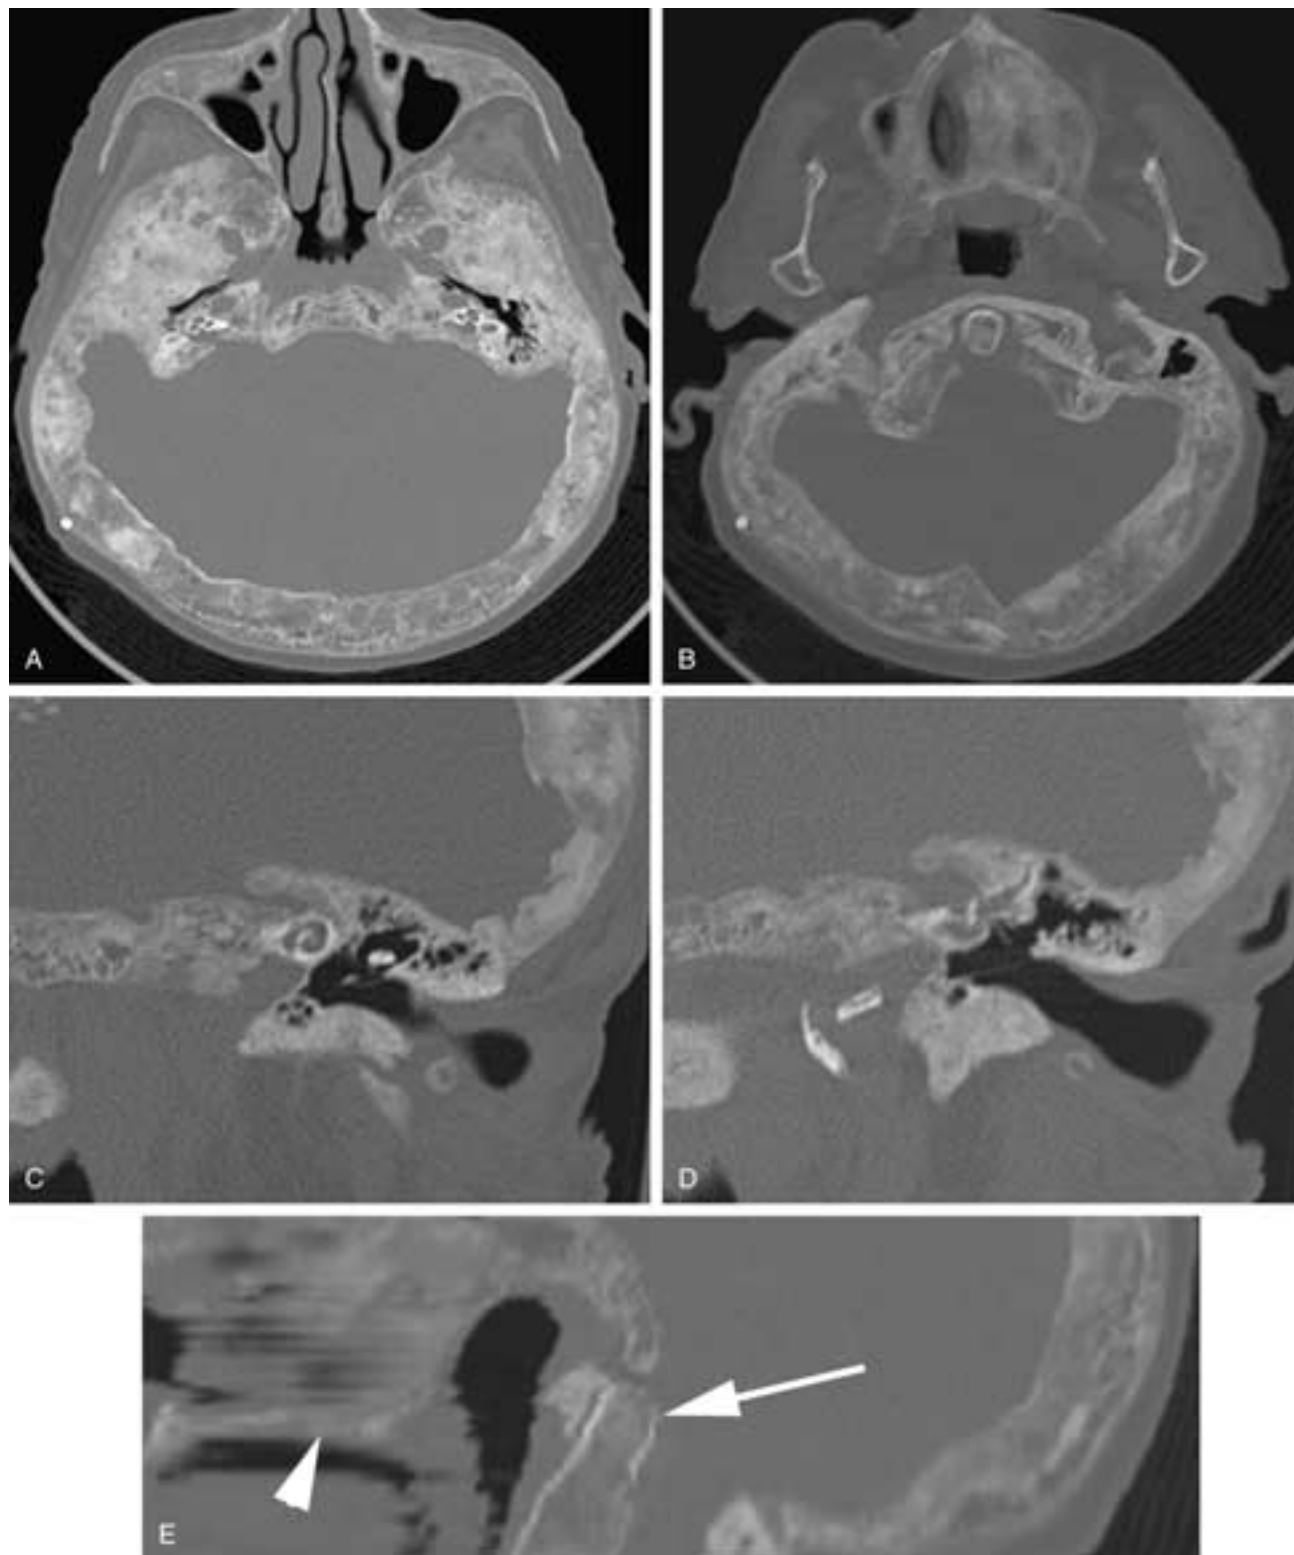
Paget's disease. A and B, Axial CT images demonstrate marked thickening of the bony structures with mixed densities of osteosclerosis and osteolysis. The changes are symmetric. Thinning of the cochlear capsule is noted bilaterally. The odontoid process protrudes above the foramen magnum to the level of the clivus. C and D, Coronal CT images show thickening of the bony structure and loss of the normal density of the otic capsule. E, Sagittal reformatted image shows a protrusion of the odontoid process (*arrow*) into the foramen magnum. Note that the tip of the odontoid is significantly higher than the hard palate (*arrowhead*). This represents basilar invagination.
